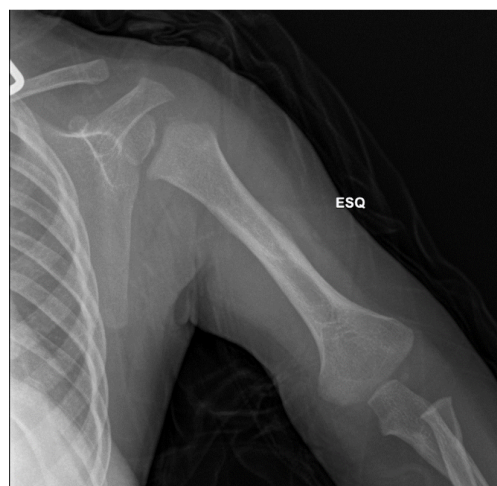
Follow-up of the left shoulder radiography obtained at one year of corrected age, demonstrating almost complete resolution of the previous structural lesions.
